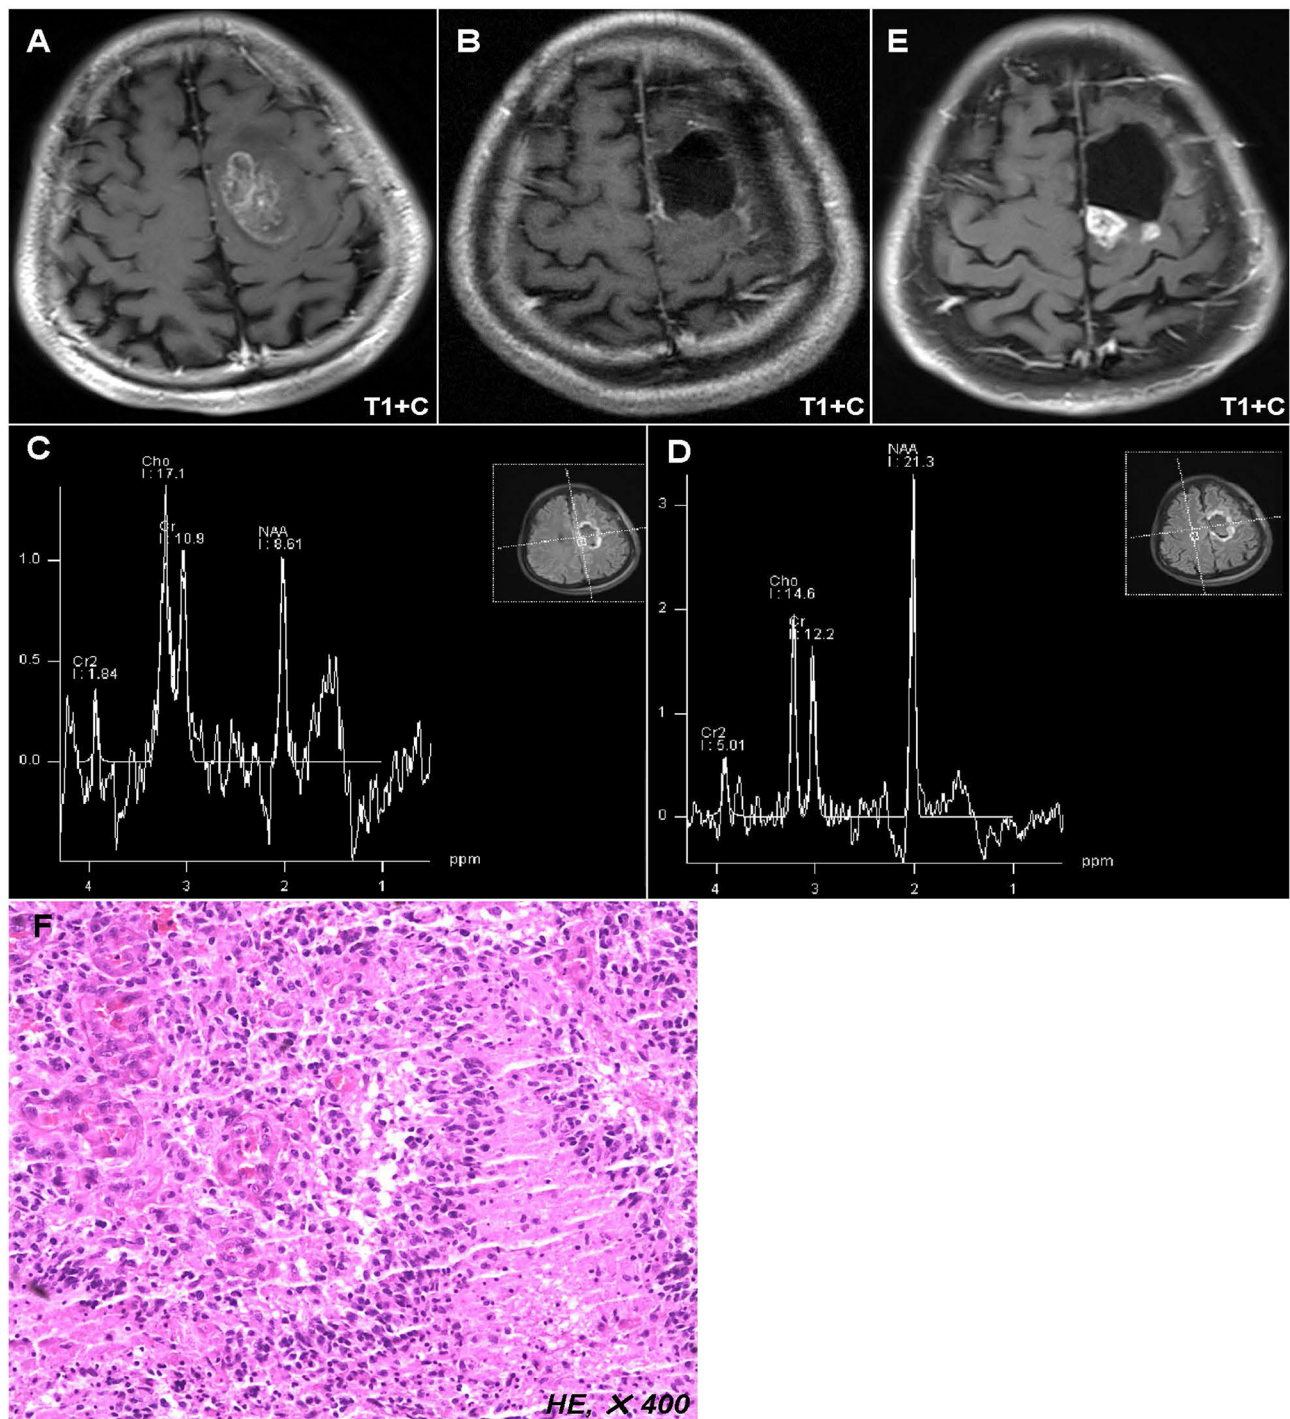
Representative case of this study. Preoperative MR images showed a lesion located in the left anterior central gyrus and supplementary motor area (A). Postoperative MR images displayed that the tumor has been totally removed (B), while the postoperative peritumoral zone showed a higher ratio of Cho/NAA (>1.31) than that in the contralateral region (C,D). Twelve months after operation, the MR images showed a new enhanced lesion in the peritumoral zone (E), which was further confirmed as tumor recurrence by biopsy (F).
